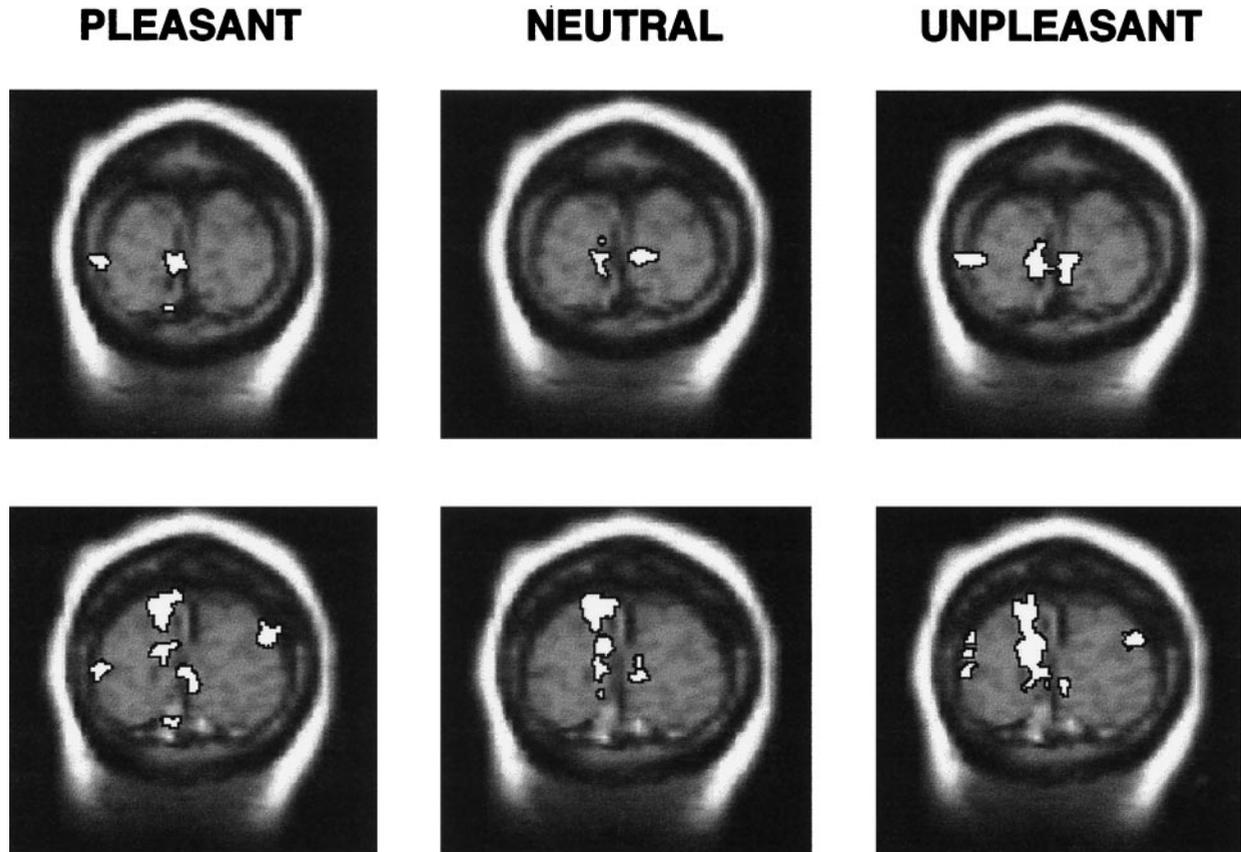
Top: Sites of functional activity during processing of pleasant (left column), neutral (center column), and unpleasant (right column) pictures, compared to no picture processing, as determined from averaging functional maps across subjects. Pixel clusters meeting criteria are depicted in outlined white, located on two successive coronal slices 5 mm thick, with the most anterior slice approximately 10 mm from the occipital pole. Top row: In this most anterior slice, all stimulus picture contents show activity centered on the calcarine fissure; only emotional pictures are beginning to show activity in the right occipital gyrus (MRI view, i.e., from an anterior perspective). Second row: All picture contents continue to show activity centered on the calcarine fissure, as well as in a portion of Area 18 directly above the calcarine fissure. Only emotional pictures show bilateral activity in the occipital gyrus (Lang et al, 1998). Bottom: Functional activity in the right posterior occipital cortex during processing of emotional and neutral pictures for men and women. Women show significantly more activation for unpleasant than pleasant pictures; men tend to show an opposite effect, greater activation for pleasant than unpleasant stimuli.
